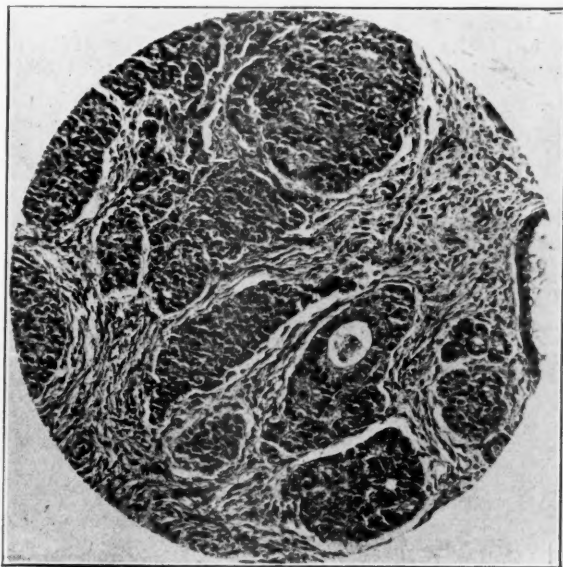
Endometrial hyperplasia, adenocarcinoma after three doses of radium 400 mg. hr. (1923, 1924, 1929), and three doses of roentgen ray (300 r in 1929, 305 r in 1933, and 600 r in 1935). ($\times 200$.)
